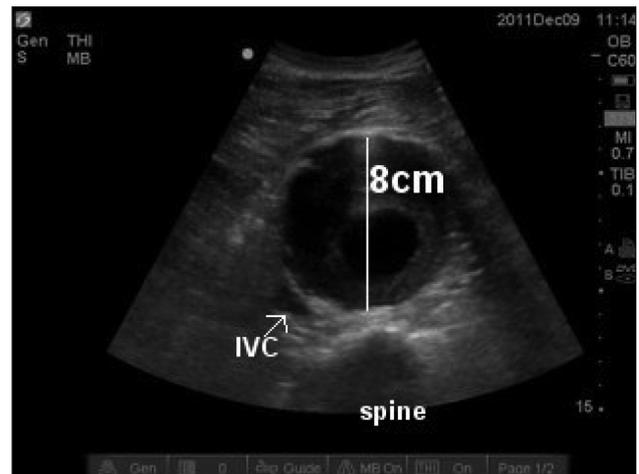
Ultrasound showing an abdominal aortic aneurysm measuring 8 cm, the widest diameter measured wall to wall. IVC = inferior vena cava.
